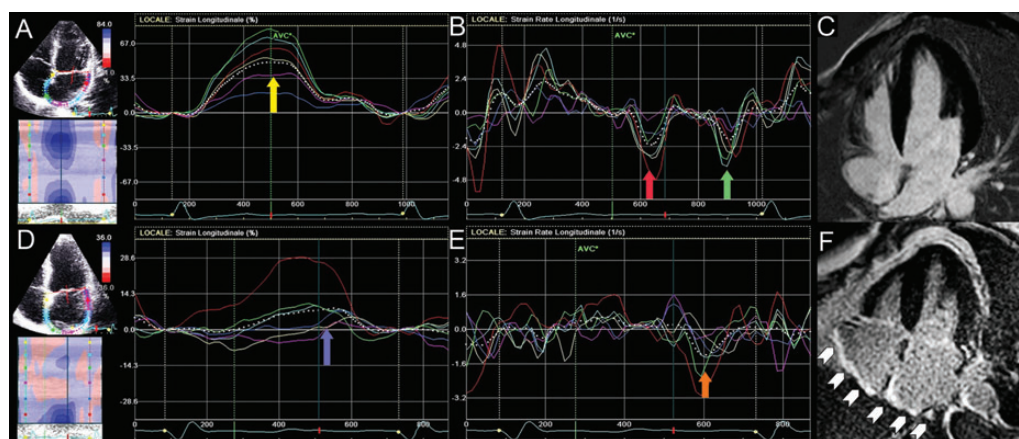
Transthoracic echocardiography in the four-chamber view showing global left atrial (LA) longitudinal strain in a normal subject. The positive peak (yellow arrow) represents an atrial preserved reservoir phase, which occurs during ventricular systole (A). Transthoracic echocardiography in the four-chamber view showing global LA longitudinal strain rate in a normal subject. During ventricular diastole it is possible to identify two negative peaks, the first corresponding to passive early LV filling (red arrow) and the second to atrial booster pump function (green arrow) (B). Cardiac magnetic resonance imaging in the four-chamber view showing a normal heart with no atrial delayed contrast enhancement and normal atrial volumes (C). Transthoracic echocardiography in the four-chamber view showing global LA longitudinal strain in a patient with permanent atrial fibrillation (AF). A reduction of positive curve during the reservoir phase (purple arrow) is expected in a patient with reduced LA compliance (D). Transthoracic echocardiography in the four-chamber view showing global LA longitudinal strain rate in the same patient. Loss of left atrial booster pump function occurs and a single negative deflection (orange arrow) can be observed during ventricular diastole, as the main pattern of AF (E). Cardiac magnetic resonance imaging in the four-chamber view showing delayed contrast enhancement in both atria (white arrow heads) and atrial dilatation in the same patient with permanent AF (F).
